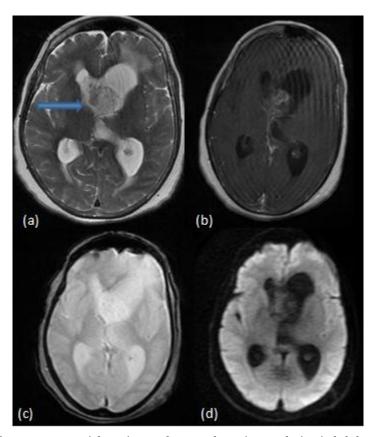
T2W axial MR image shows T2 hyperintense lesion in left frontal horn causing compression of bilateral foramen of Monroe with dilatation (arrow) of bilateral lateral ventricles (a); post-contrast T1W axial MR image shows the lesion showing heterogenous enhancement (b); GRE axial MR image shows no blooming in the lesion (d); diffusion-weighted MR image shows no diffusion restriction (d).
